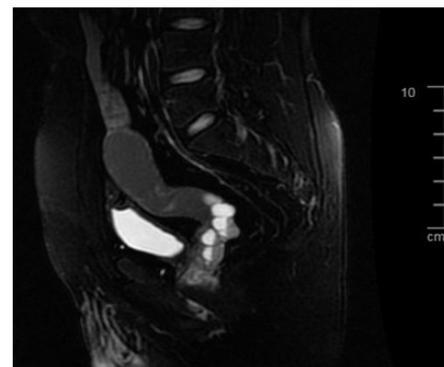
Uterus detected by MRI pelvis.
